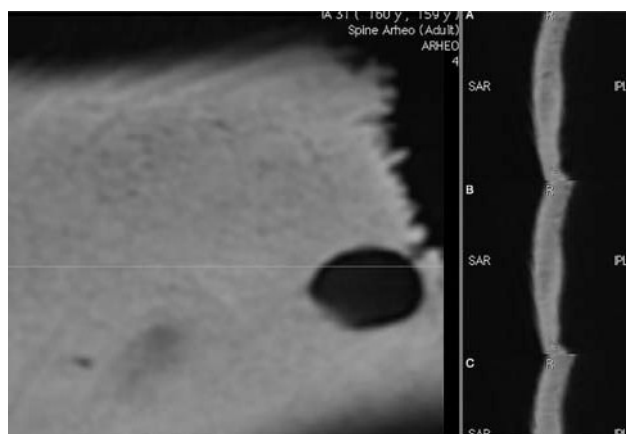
Stretched curved multiplanar reconstruction (CPR), CT scan, Bezdanjača (scan by M. Čavka).
